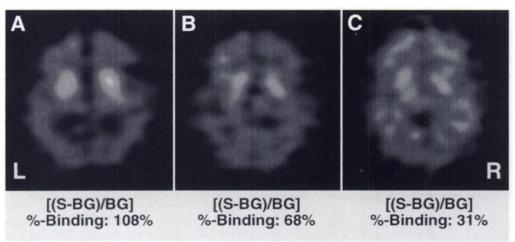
lodine-123-IBZM SPECT images of  $D_2$  receptor binding at equilibrium. (A) Drug-naive schizophrenic patient. (B) Schizophrenic patient receiving treatment with risperidone at daily dosage of 37  $\mu$ g/kg body weight. (C) The same patient treated with daily dosage of 100  $\mu$ g/kg body weight.
